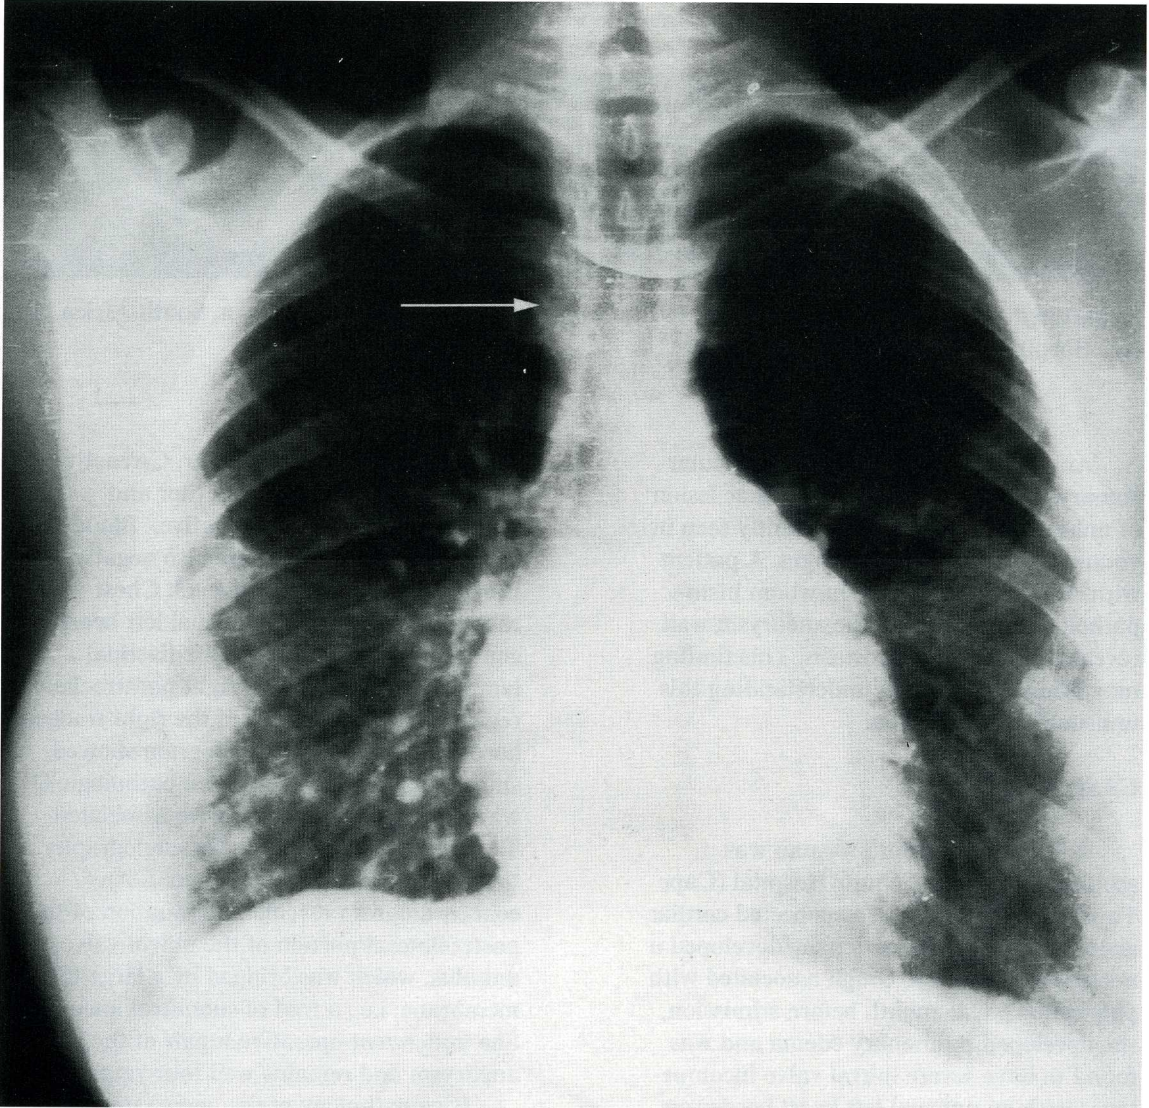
Chest x-ray demonstrating unusual left cardiac border with irregular mass in right paratracheal region with compression of the trachea (arrow)
